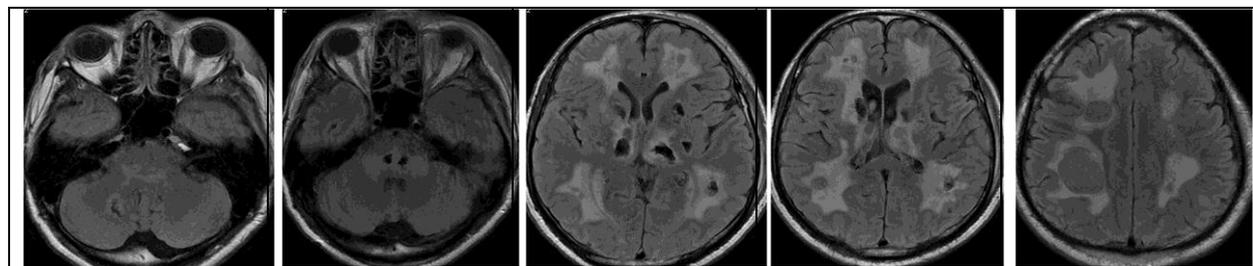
(A-E): FLAIR axial images show increased intensity of the cysts than that of the CSF.
